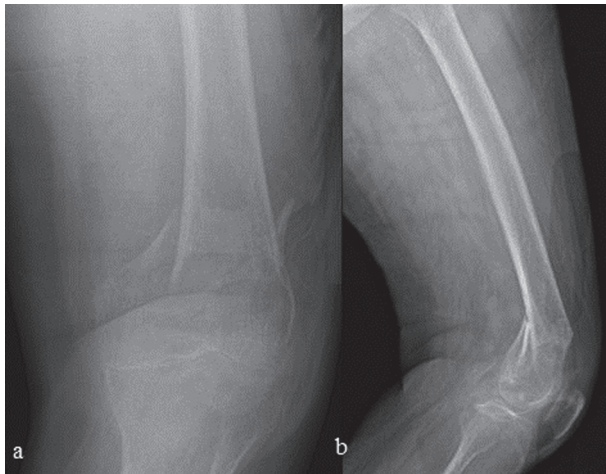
AP (a) and lateral (b) radiographs of a distal femur fragility fracture in a 90 years old woman with severe osteoporosis
